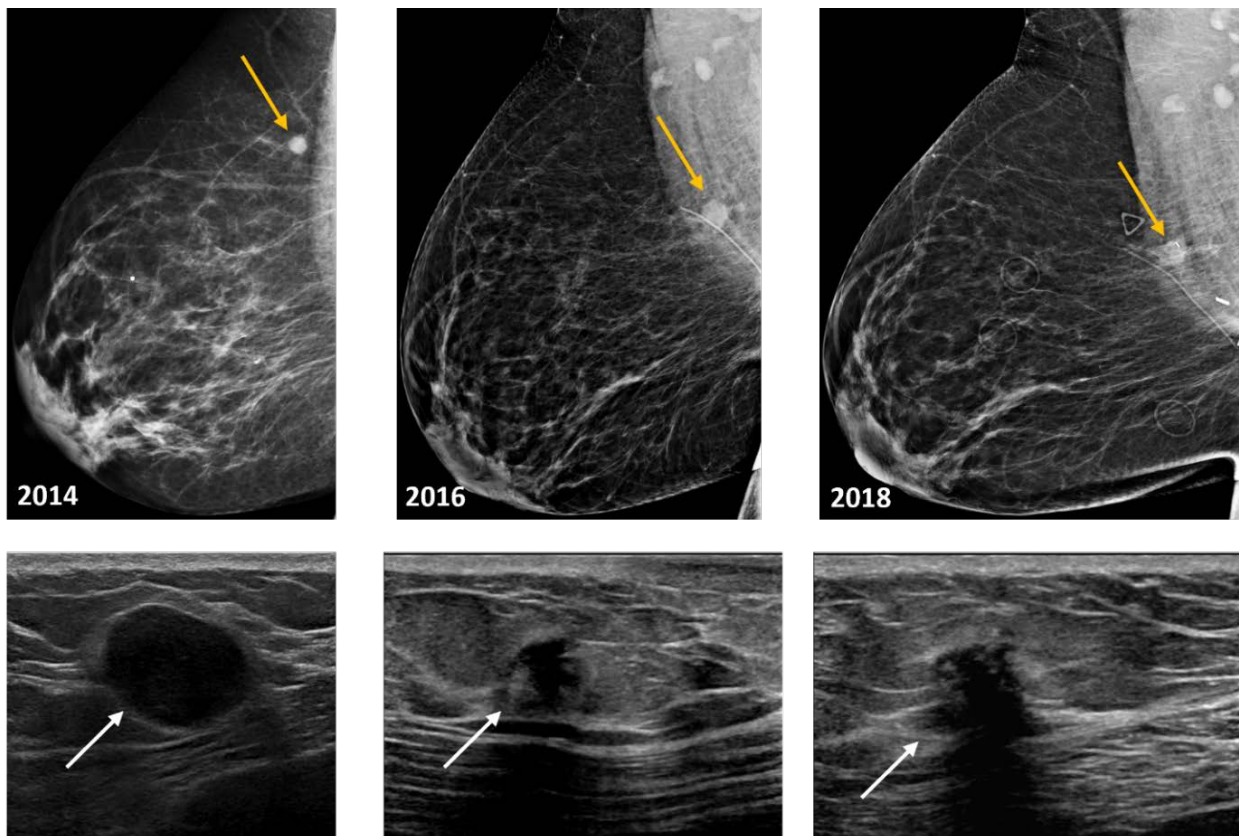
Recurrent granular cell tumor: A 47-year-old woman first presented in 2014 with a right breast palpable lump. On mammography, she had a 0.8cm round, circumscribed, equal density mass which was oval, parallel, circumscribed, and hypoechoic by sonography. She underwent surgical excision after her biopsy revealed a benign granular cell tumor. A recurrent 1.2cm mass in the surgical bed was found 2 years later. A repeat biopsy revealed recurrent granular cell tumor. The patient opted not to undergo a repeat surgical excision. The mass was stable in the 2018 mammogram. The patient was unavailable to follow-up as she relocated to a different state. The recurrent mass had non-circumscribed margins on mammography and sonography.
